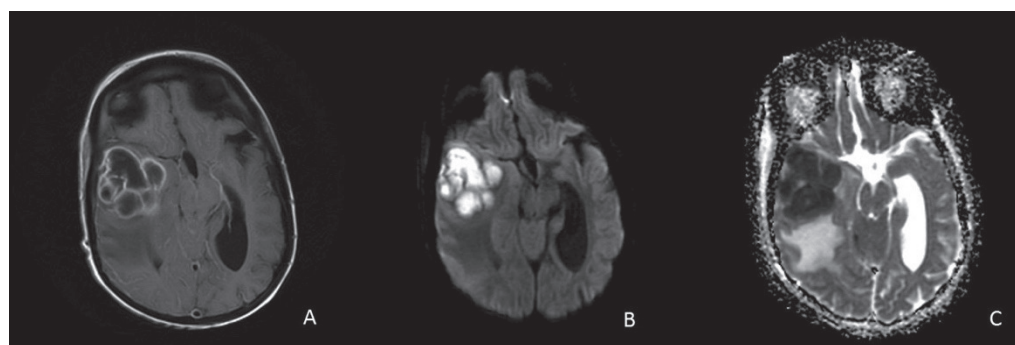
(A) Brain abscess with peripheral contrast enhancement in the right temporal lobe. (B, C) Reduced signal intensity on diffusion magnetic resonance images
